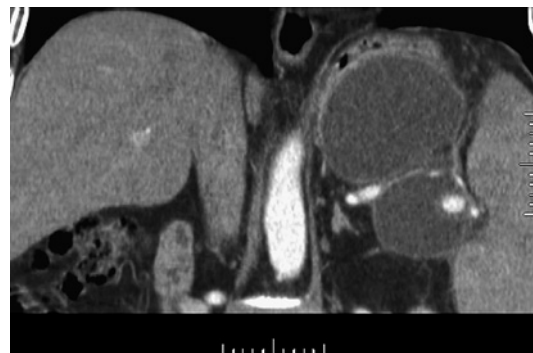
Pseudo-aneurysm from the splenic artery by CT scan.
